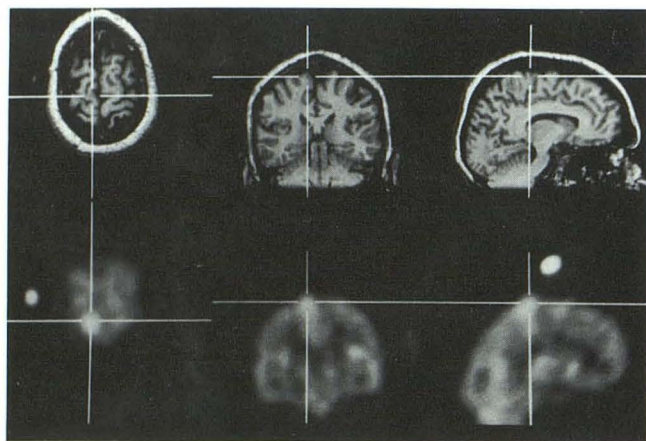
An ictal scan in a patient with presumed Rasmussen encephalitis. The MR demonstrates a prominent gyrus (upper arrow) which corresponds with the area of increased perfusion on SPECT (lower arrow). From the correlated images, we postulate that the patient's condition at the time of imaging studies (focal motor status epilepticus) was a result of ongoing cortical inflammation involving the premotor cortex and adjacent motor strip. Note the atrophy of the frontal lobe inferior to this area on the coronal MR and the corresponding hypoperfusion on SPECT.
